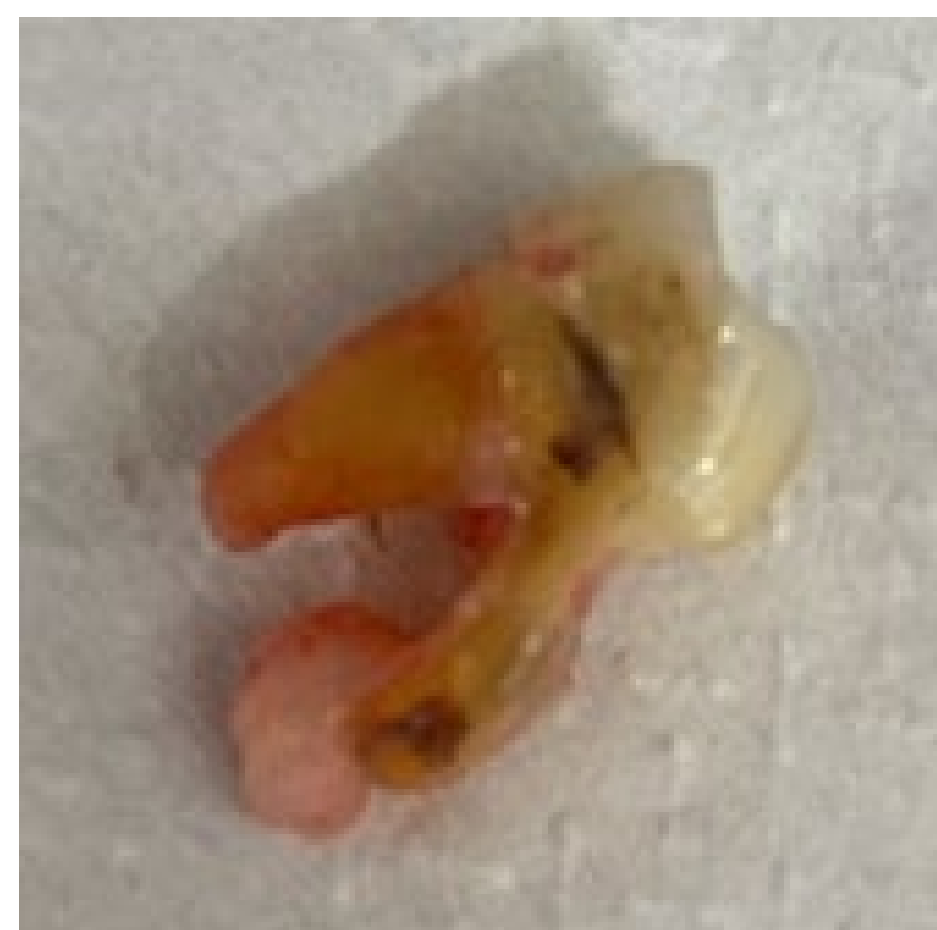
Extracted #14 and periapical tissues attached to the apex of palatal root
